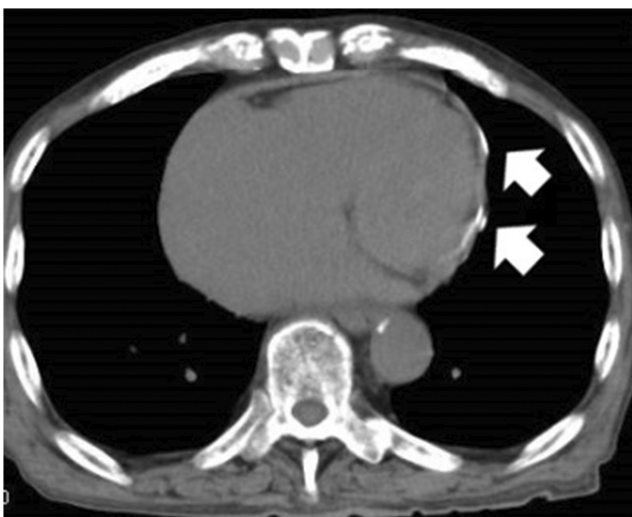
Computed tomography revealing partial calcification of the pericardium (white arrows).
